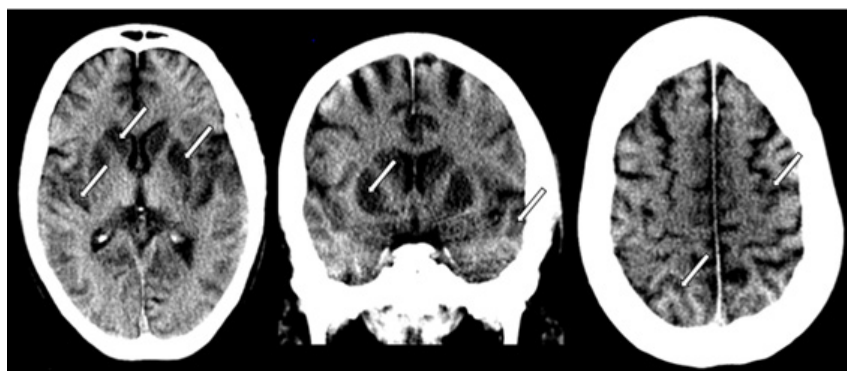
Brain CT scan demonstrates brain volume loss associated with hypodensity in the cerebral cortex bilaterally, as well as in the putamina and caudate nuclei, indicative of severe hypoxic-ischemic injury.
